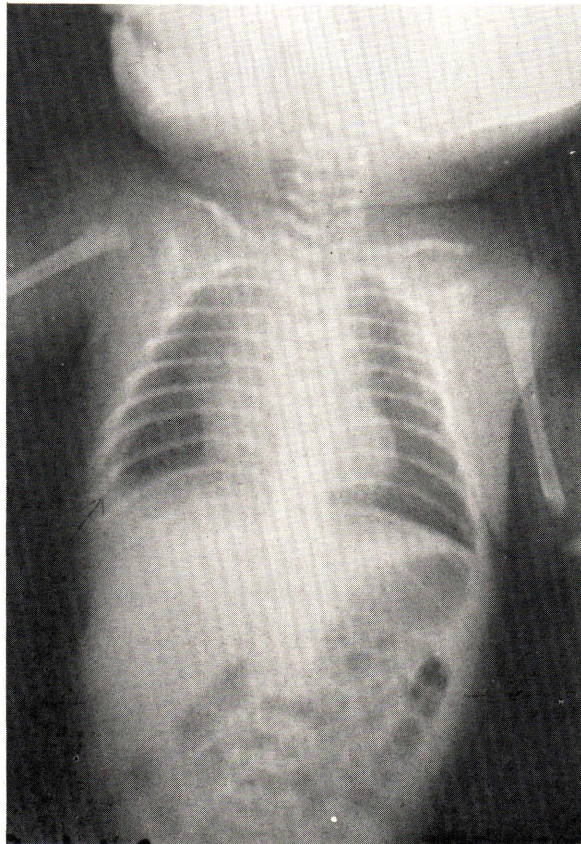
Chest x-ray film taken on the 2nd day of life showed hyperaeration and minimal Rt. pleural effusion (arrow).
